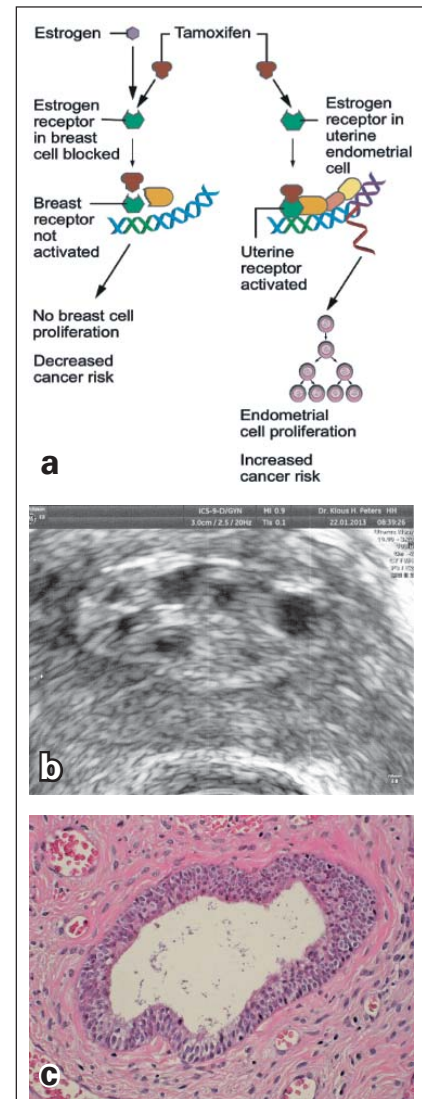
Tamoxifen: Induction of endometrial cancer. (a) Flow sheet. Mod. from National Cancer Institute. © Thomas Rabe; (b) Endometrial changes by tamoxifen shown by ultrasound (Peters, Hamburg, reprint with permission); (c) Hyperplasia of the endometrial cells in fibrous stroma under tamoxifen therapy (62 years, 12981/2014 HE 20x). © Thomas Rabe.
